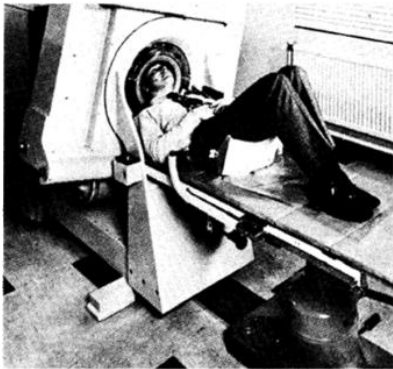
First CT scanner and 1st image of the brain
